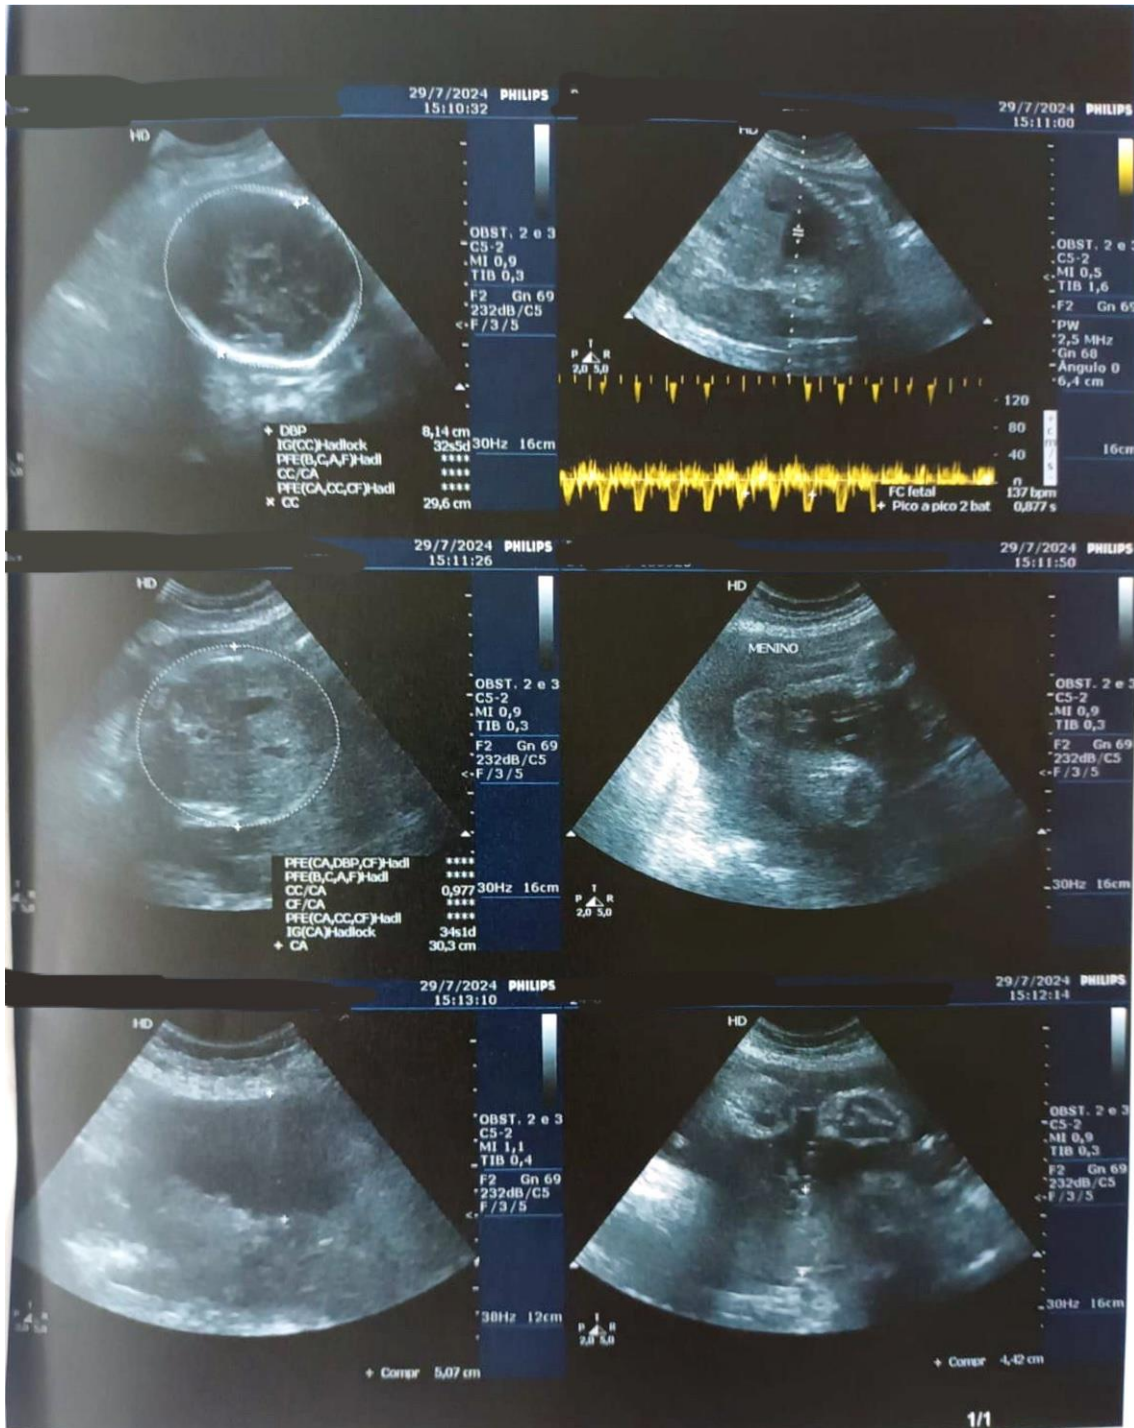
Ultrasound image taken on July 29, 2024, at 32 weeks and 1 day of gestation. The scan shows an Abdominal Circumference (AC) of 303 mm and Femur Length (FL) of 64 mm, both above the 97.5th percentile, indicating accelerated fetal growth. The Estimated Fetal Weight (EFW) was 2,269 g, also above the 97.5th percentile, with no additional abnormalities in placental or fetal morphology observed at this time.
